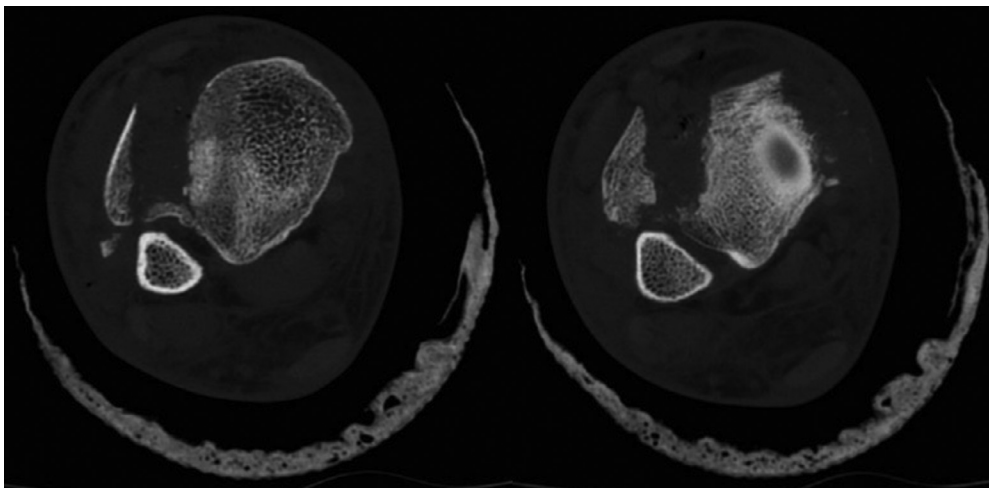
Preoperative computed tomography scan showing the Tillaux-Chaput fragment, axial view.
